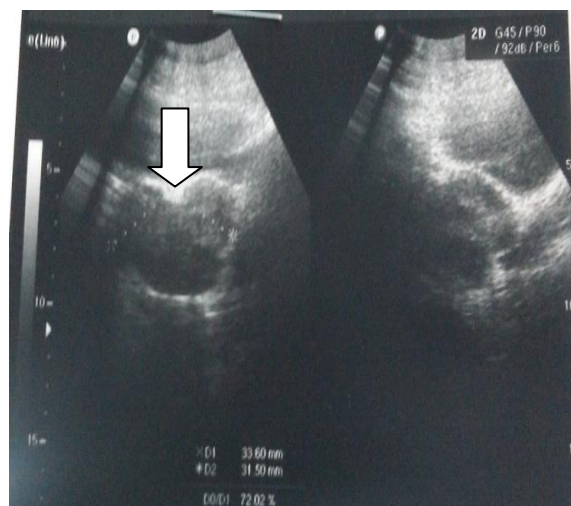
Trans-abdominal ultrasound of the pelvis transverse and longitudinal views showing a fundal defect with two cornua of the uterus (arrow).
